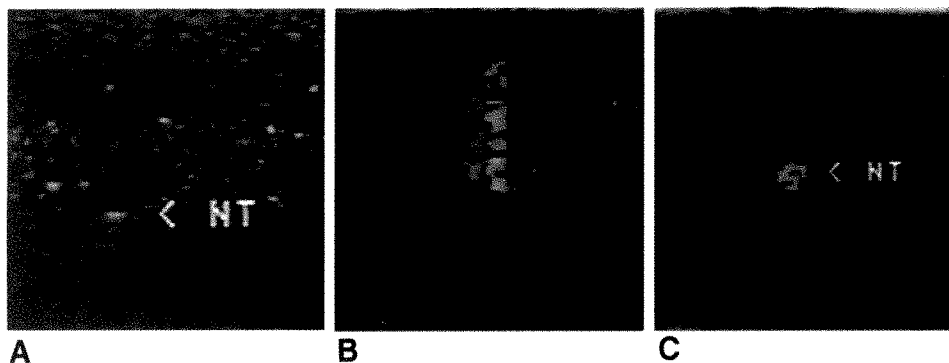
A, Tip (NT) of 22-gauge spinal needle produces faint echo within gel standoff pad on color Doppler sonogram.
